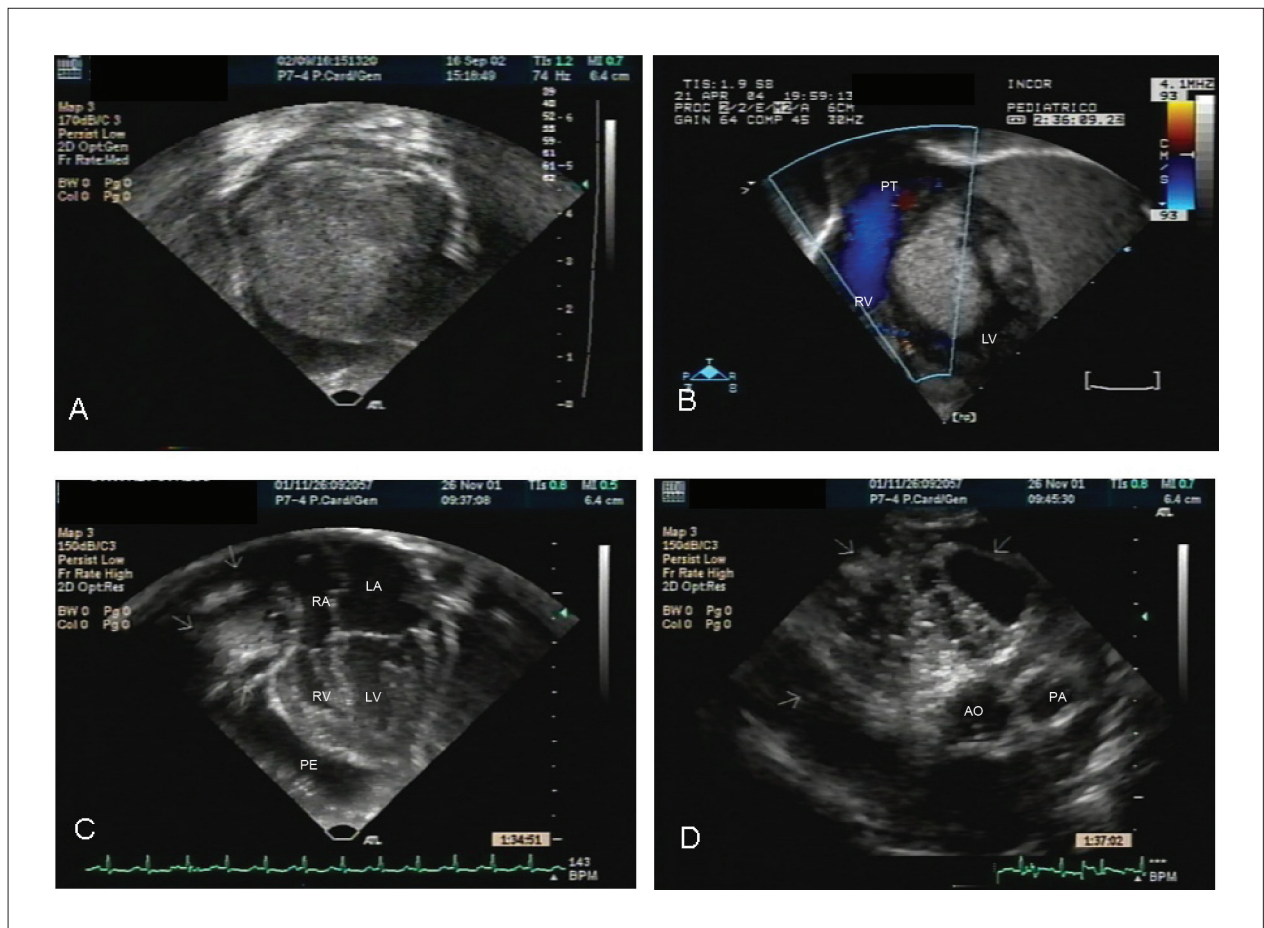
1a – Echocardiographic image showing the left ventricle (LV) with its cavity nearly filled by the tumor mass (arrows), measuring 3 x 2 cm, later identified as a fibroma. This patient (case #9) was 3 hours old, asymptomatic, with a fetal diagnosis of heart tumor and pericardial effusion. Surgical treatment was based on tumor biopsy and pericardial drainage due to tumor extension, which showed no cleavage plane. 1b – Echocardiogram in parasternal view, of neoplasm (arrows) affecting the left ventricle (LV), with free outflow tract. The neoplasm was classified as a rhabdomyoma after pathological analysis (case #6). PT: pulmonary trunk, RV: right ventricle, LV: left ventricle. 1c – Echocardiogram in four-chamber view showing neoplasm (immature cystic teratoma - arrows) compressing the right atrium (case #11). RA: right atrium, LA: left atrium, RV: right ventricle, LV: left ventricle, PE: pericardial effusion. 1d – Echocardiogram in parasternal view of immature cystic teratoma (arrows) in the region adjacent to the great vessels (case #11). AO: aorta, PA: pulmonary artery.
